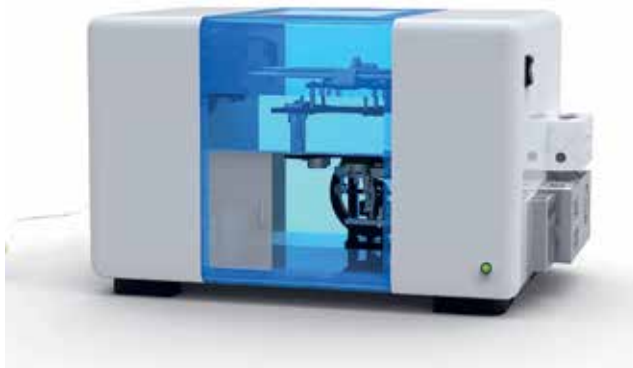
Verdopplerbot system.
